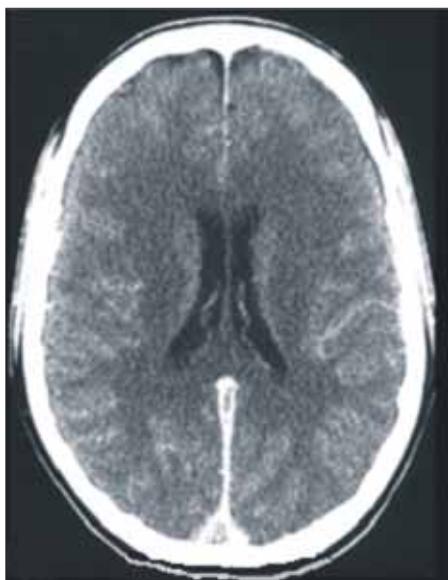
(unenhanced CT scan). Dense triangle in a recent S.S.S. thrombosis. The thrombus is hyperdense (arrow).
